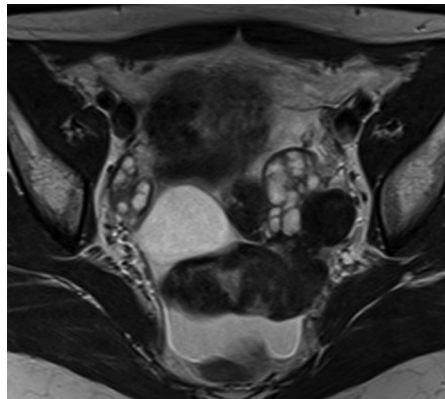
Axial T2WI revealing a left ovarian fibroma with markedly low-SI. T2WI, T2-weighted imaging; SI, signal intensity.
